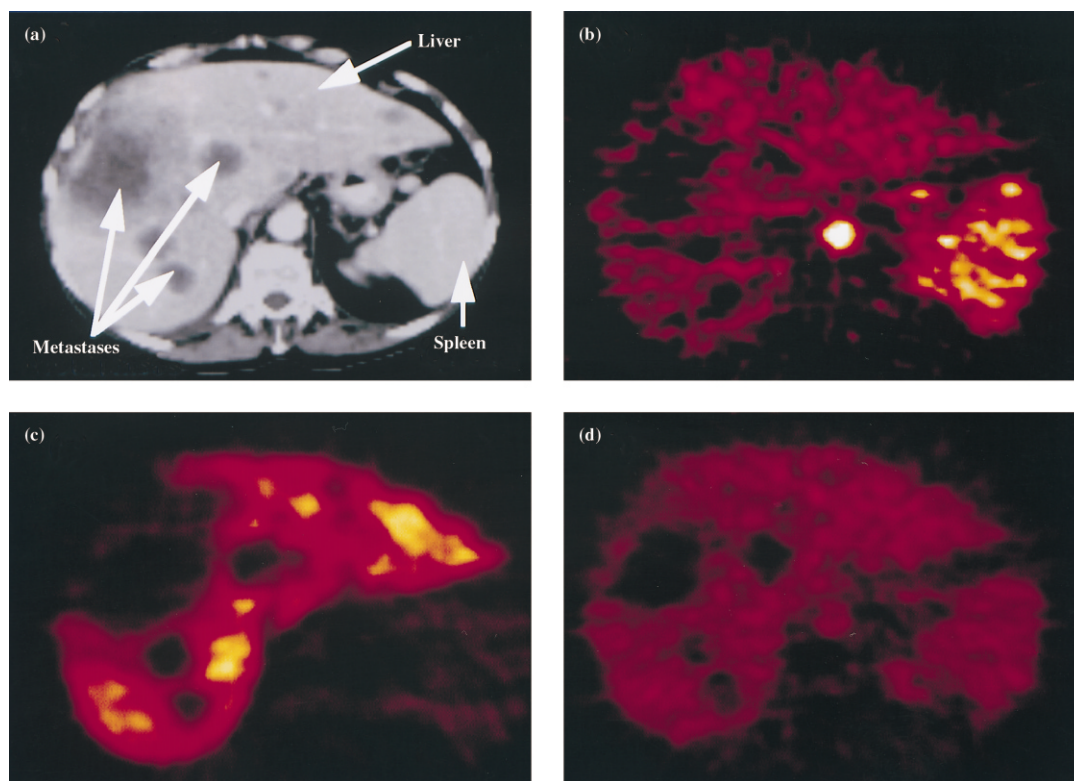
Transabdominal computed tomography (a) and corresponding positron emission tomography (PET) blood flow (b) and PET ^{18}F -fluorouracil images without eniluracil (c) and after eniluracil (d), showing liver, spleen and multiple hepatic metastases. Reproduced with permission [87].
